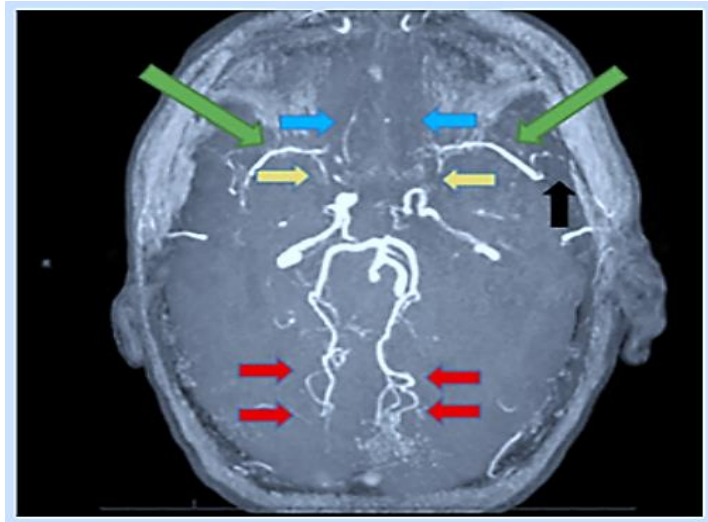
Cerebral angio-MRI confirming MMD from vascular abnormalities
